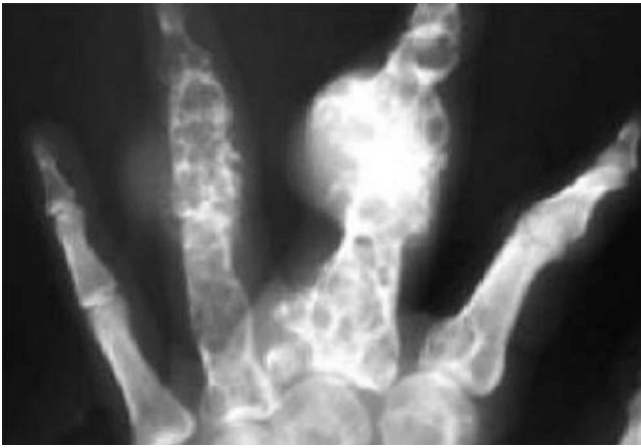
X-ray findings of multiple enchondroma in the left hand
